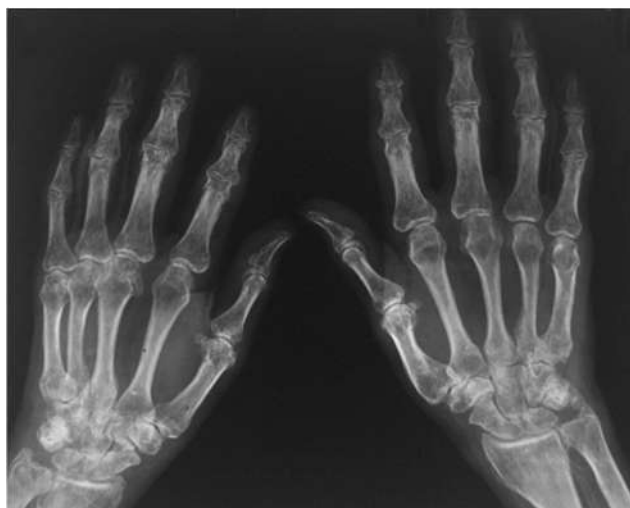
Radiograph of the wrist showing periarticular osteopenia, osteophytes, and degenerative changes predominantly at the left radiocarpal and interphalangeal joints
